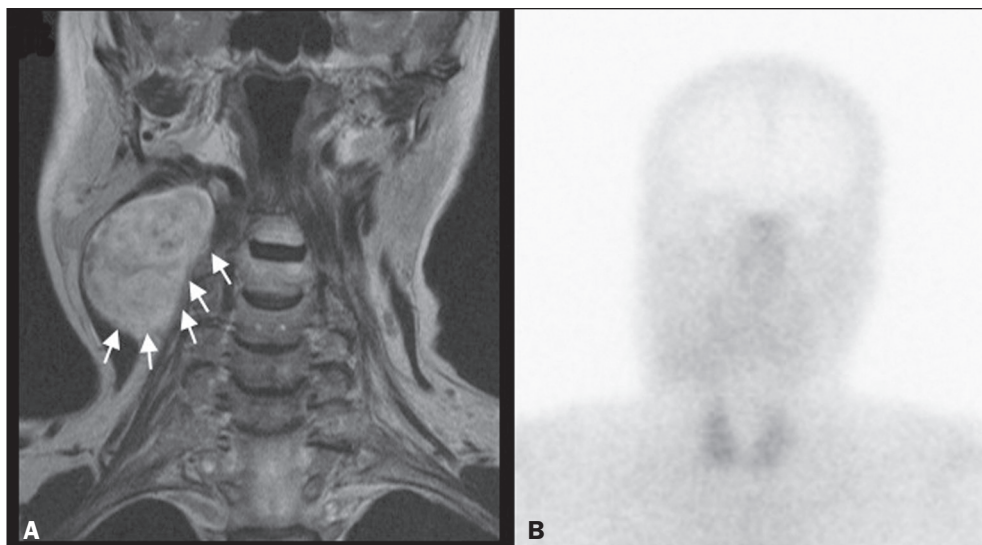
MRI and SRS images of patient A3, who received a confirmed diagnosis of schwannoma. Coronal contrast-enhanced T1W image (A) depicting a fusiform lesion (arrows) interposed between the right carotid artery and internal jugular vein, extending superiorly to the skull base. SRS did not detect somatostatin receptor overexpression (B).
